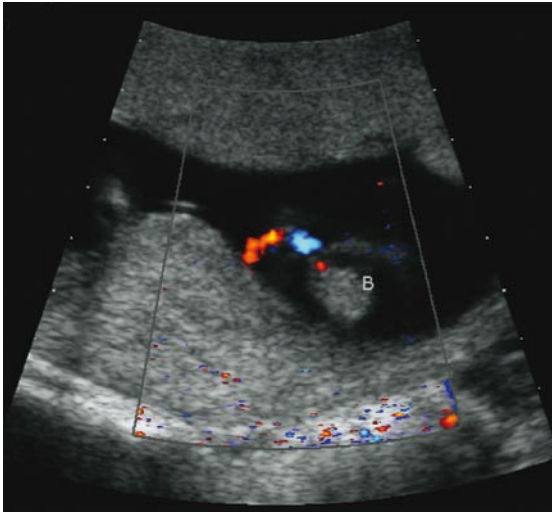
Colour Doppler US image taken at 15 weeks gestation shows reversed arterial perfusion through Twin B.
